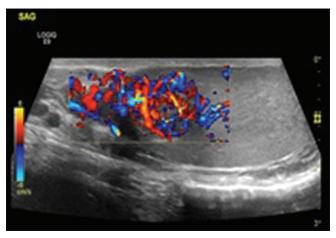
Scrotum Doppler (hypervascularized testicular mass)
